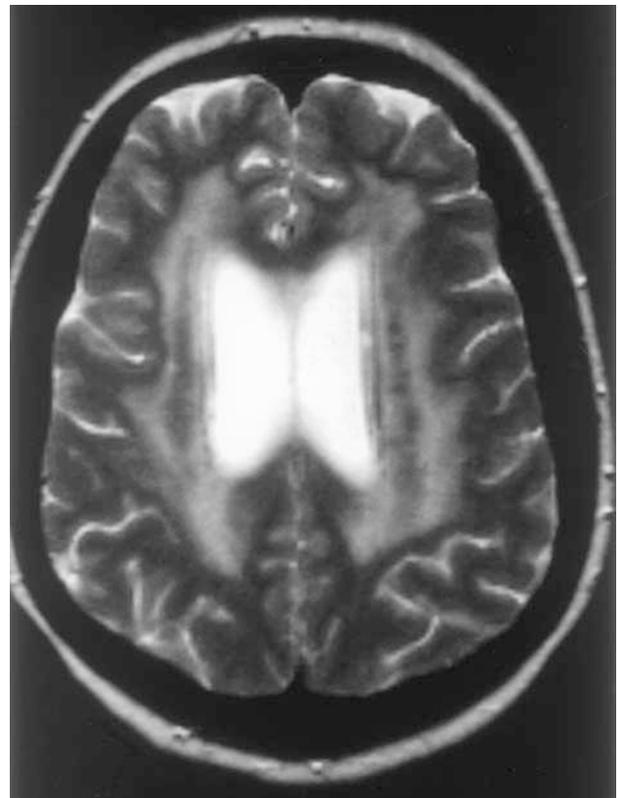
T2-weighted axial MRI brain scan. Large areas of increased signal reflecting widespread, diffuse ischaemic damage to both cerebral hemispheres.
